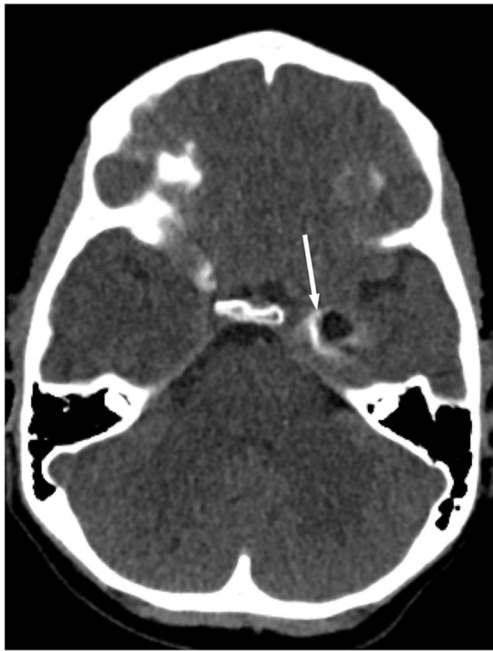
Dysembryoplastic neuroepithelial tumor (DNET) in a 4-year-old boy with temporal lobe epilepsy. Nonenhanced CT axial image shows a hypodense and partially calcified mass in the anteromedial left temporal lobe involving the white matter and the overlying cortex with no significant mass effect or edema (*arrow*)
